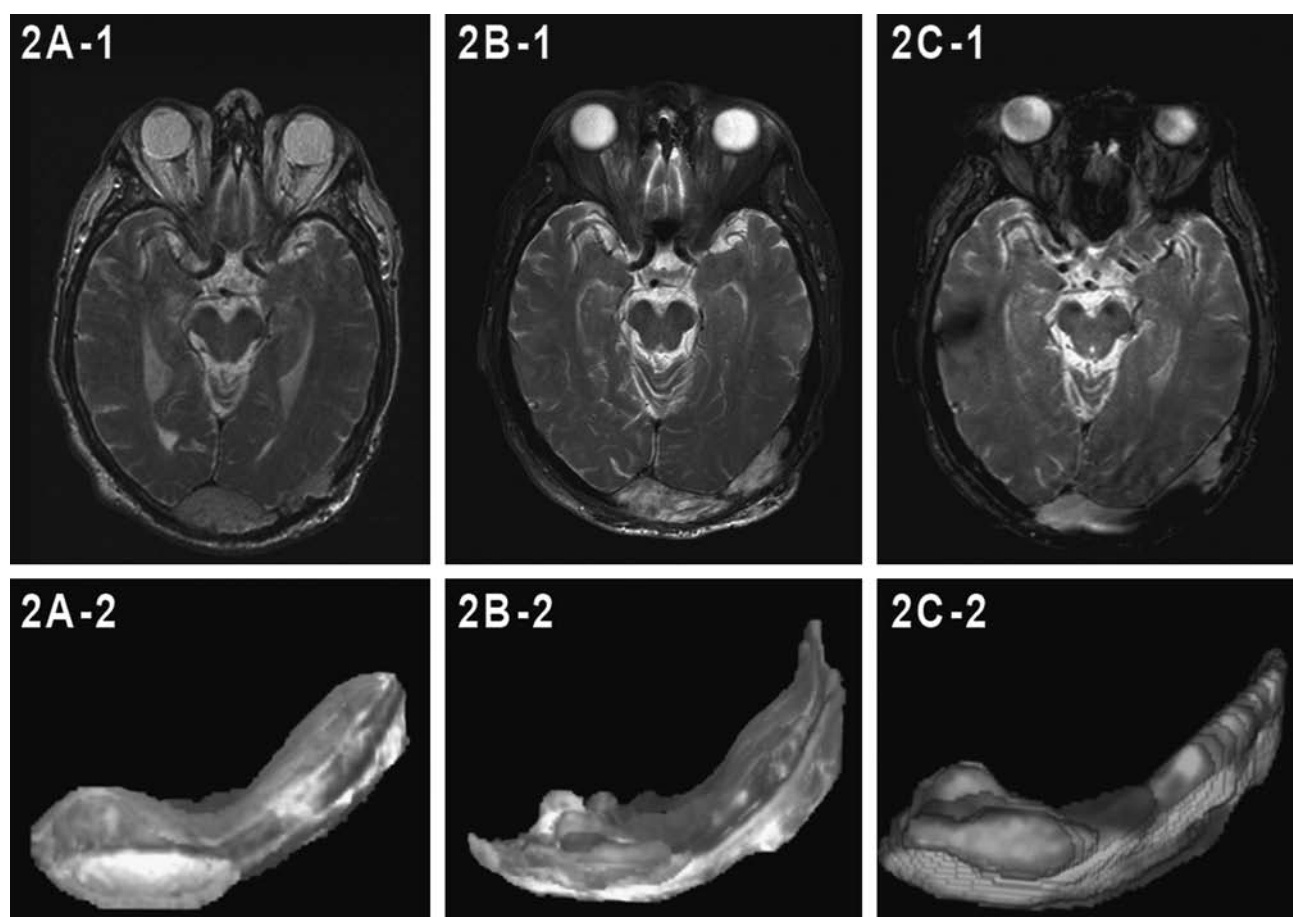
MRI transaxial images of the patient's head at the same anatomic level over time during thyroxine therapy. Tumor was electronically isolated. (A) January 2007; TSH (in May) 0.4 mU/L; 2A-1 MRI and 2A-2 tumor with volume of 74 mL; (B) November 2007 (following ^{131}I treatment in July); TSH 0.4 mU/L; 2B-1 MRI and 2B-2 tumor with volume of 121 mL. (C) November 2008 (following ^{131}I treatments in July and December 2007); TSH 2.1 mU/L; 2C-1 MRI and 2C-2 tumor with volume of 72 mL. Color image available online at www.liebertonline.com/thy.
